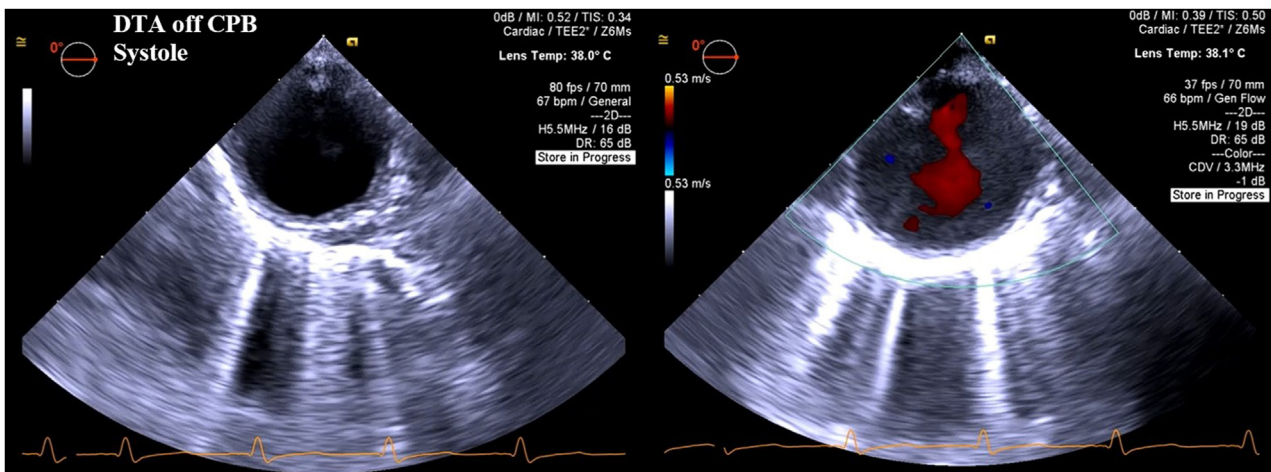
Two-dimensional TEE, midesophageal DTA short-axis systolic view without (left) and with (right) color flow Doppler after discontinuation of the CPB circuit, no longer demonstrates any evidence of an intimal dissection flap.
